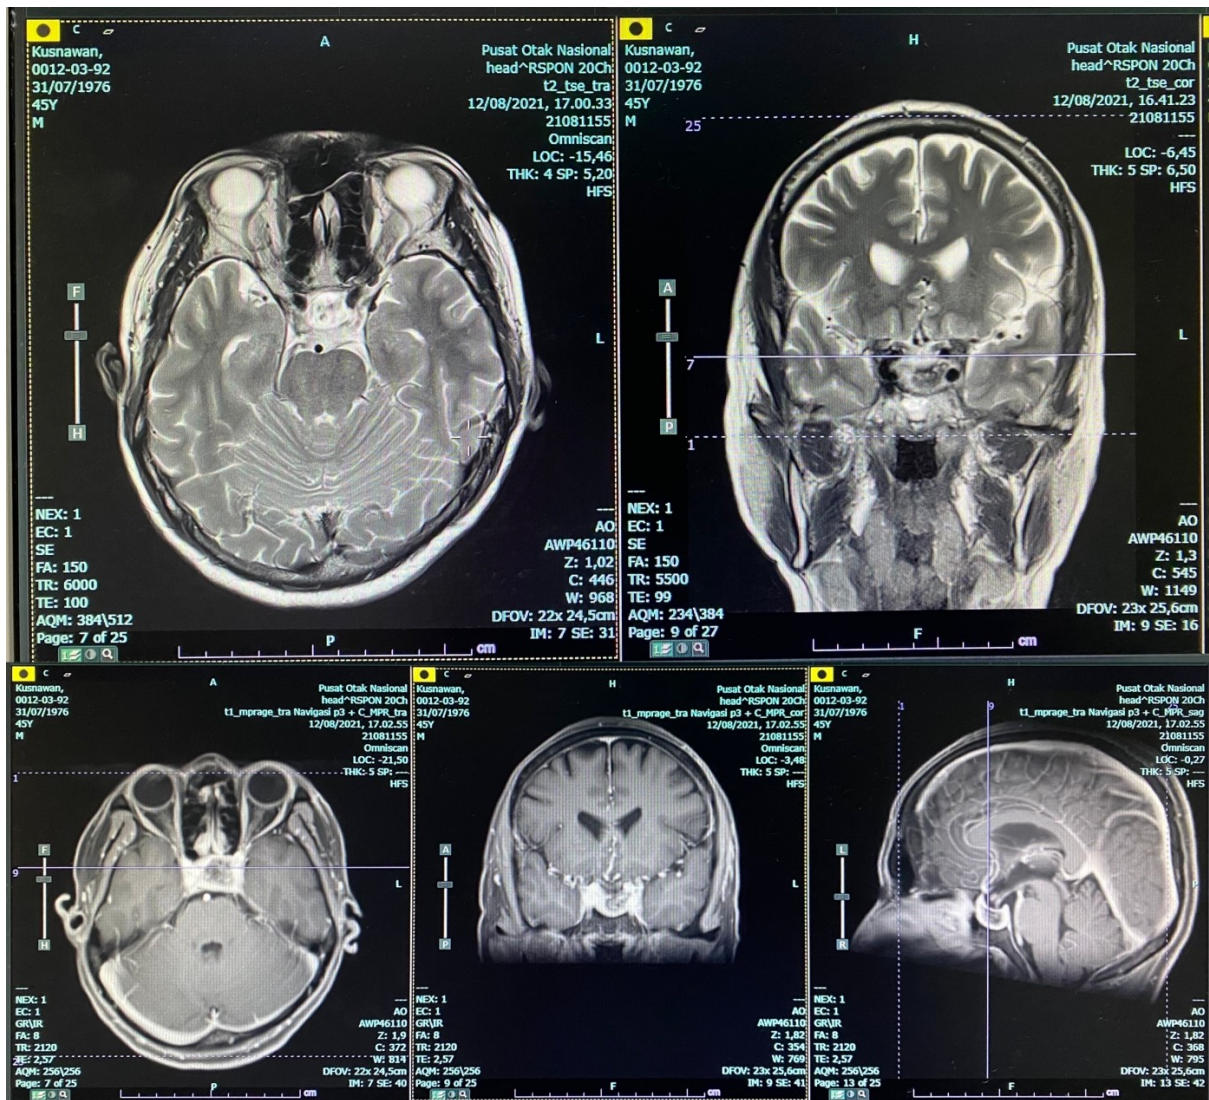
MRI T1 with Gadolinium and T2WI showed intrasellar cystic lesion between left and right internal carotid arteries.
